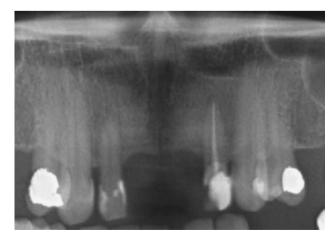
Cropped panoramic radiograph of the case
